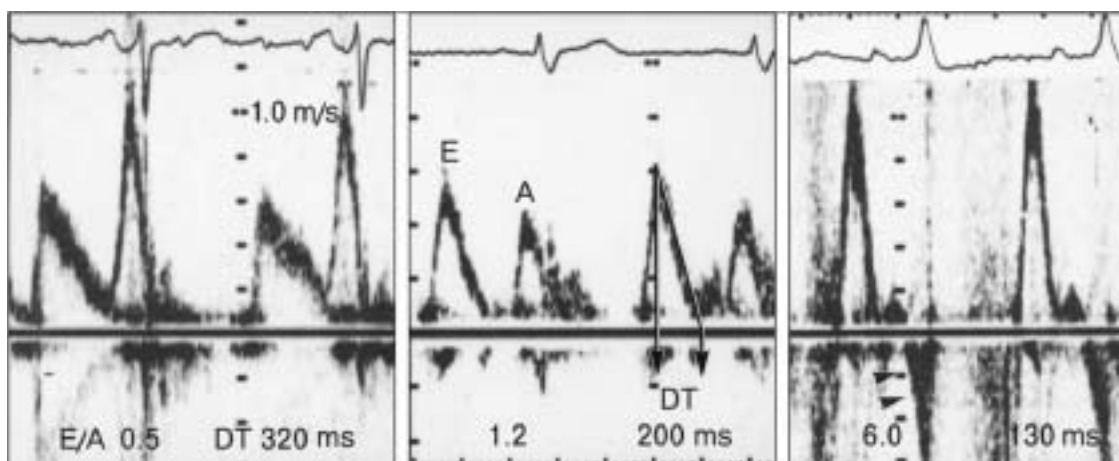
Pulsed wave Doppler recordings of mitral inflow velocity to determine diastolic filling pattern. These Doppler recordings represent impaired myocardial relaxation (left), normal (center), and restrictive diastolic filling pattern (right). In impaired relaxation pattern, which is an initial diastolic dysfunction, early diastolic velocity (E) is reduced and deceleration (DT) time is prolonged, usually longer than 240 ms. The late diastolic filling velocity at the time of atrial contraction (A) is augmented and higher than E. In normal mitral inflow velocity, E velocity is equal to or
